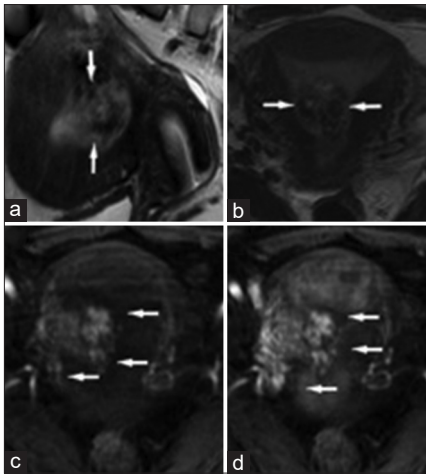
Sagittal and axial T2-weighted sequences (a and b) showing an enlarged uterus with hypointense lesion at the right lateral wall extending into the uterine cavity. After administration of intravenous contrast, marked enhancement is present in the early arterial phase (c and d). Arrows indicate myometrial and endometrial vessels
